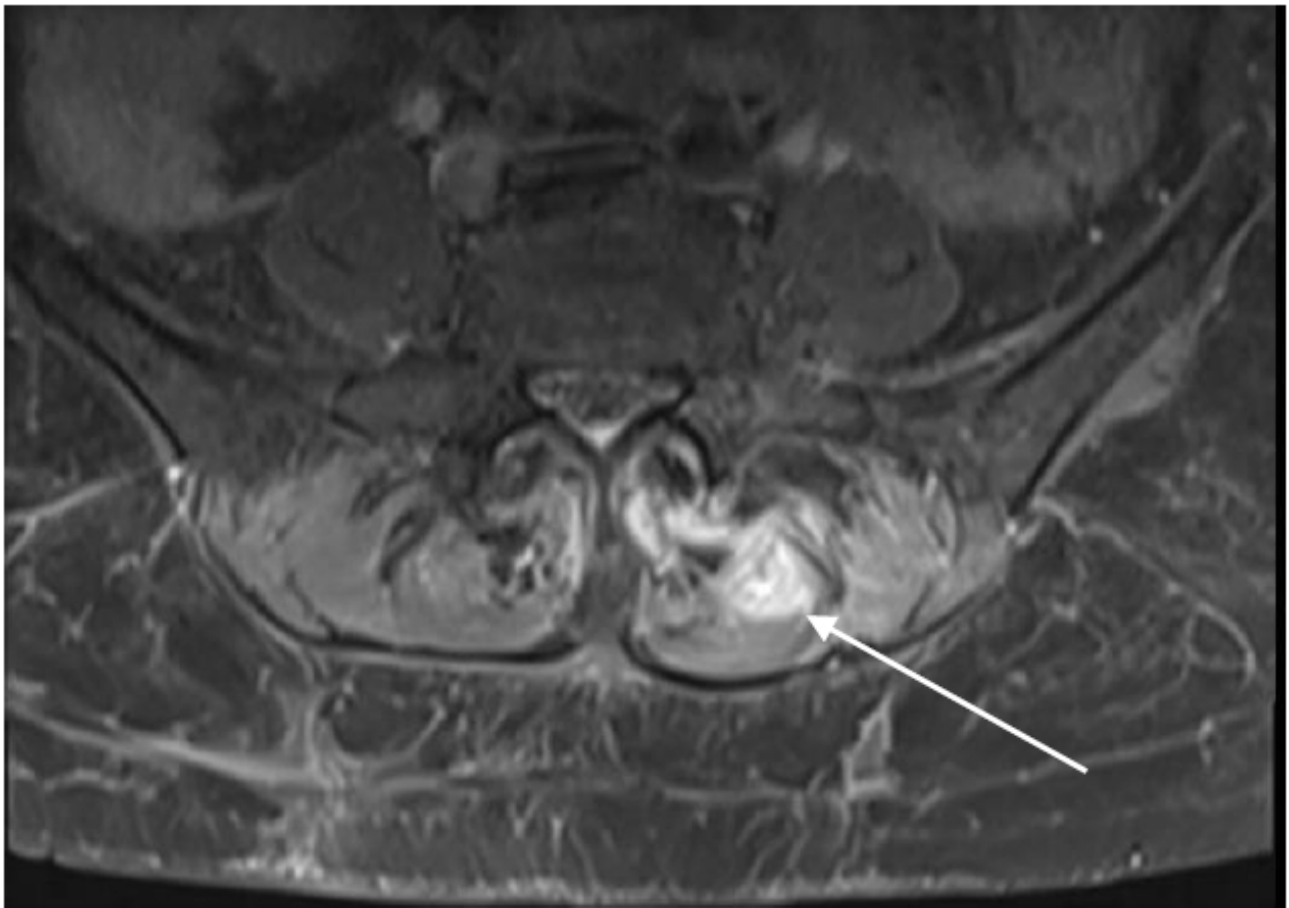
MRI (Magnetic Resonance Imaging) lumbar and sacral spine with contrast. This image shows a pronounced left-hand side L4/L5 facet joint effusion, marked by the arrow.
